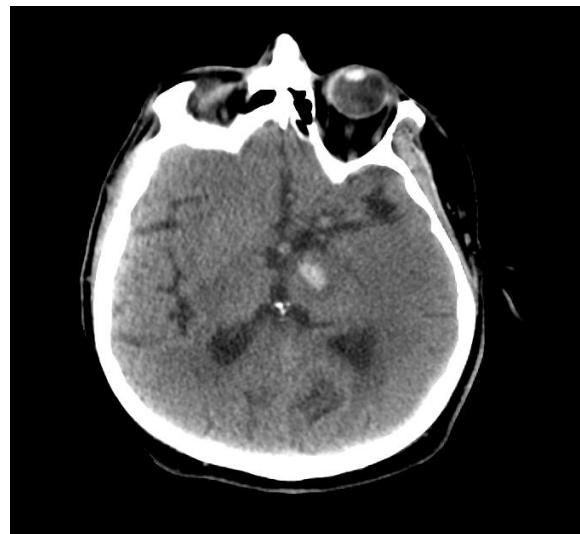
Computed tomography, axial section: Hyperdense bleeding area of approximately 1.125 ml in the left thalamus at the acute period.
